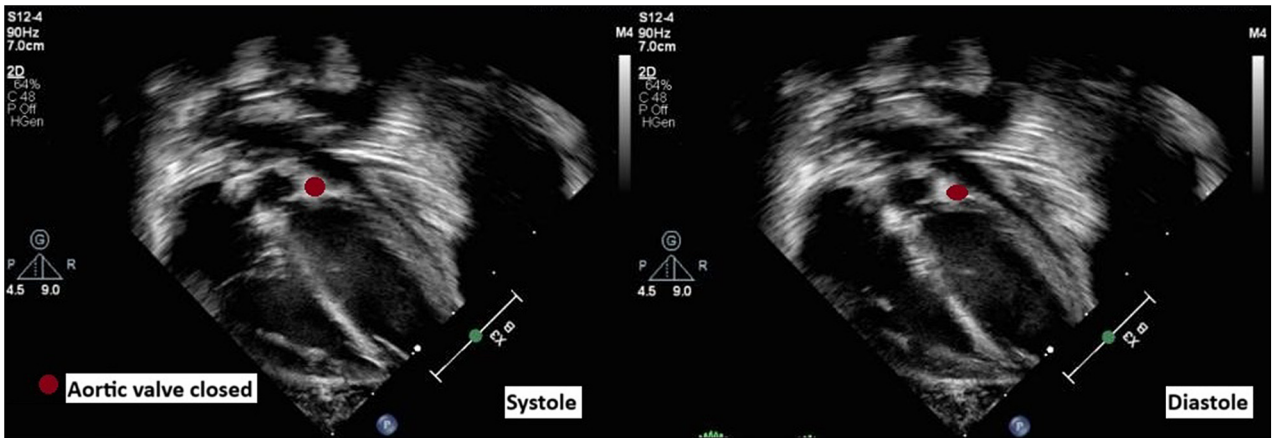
Two-dimensional transthoracic echocardiography, apical 5-chamber view in systole (left) and diastole (right), demonstrates that the aortic valve (red circle) was not opening at any point during the cardiac cycle.
